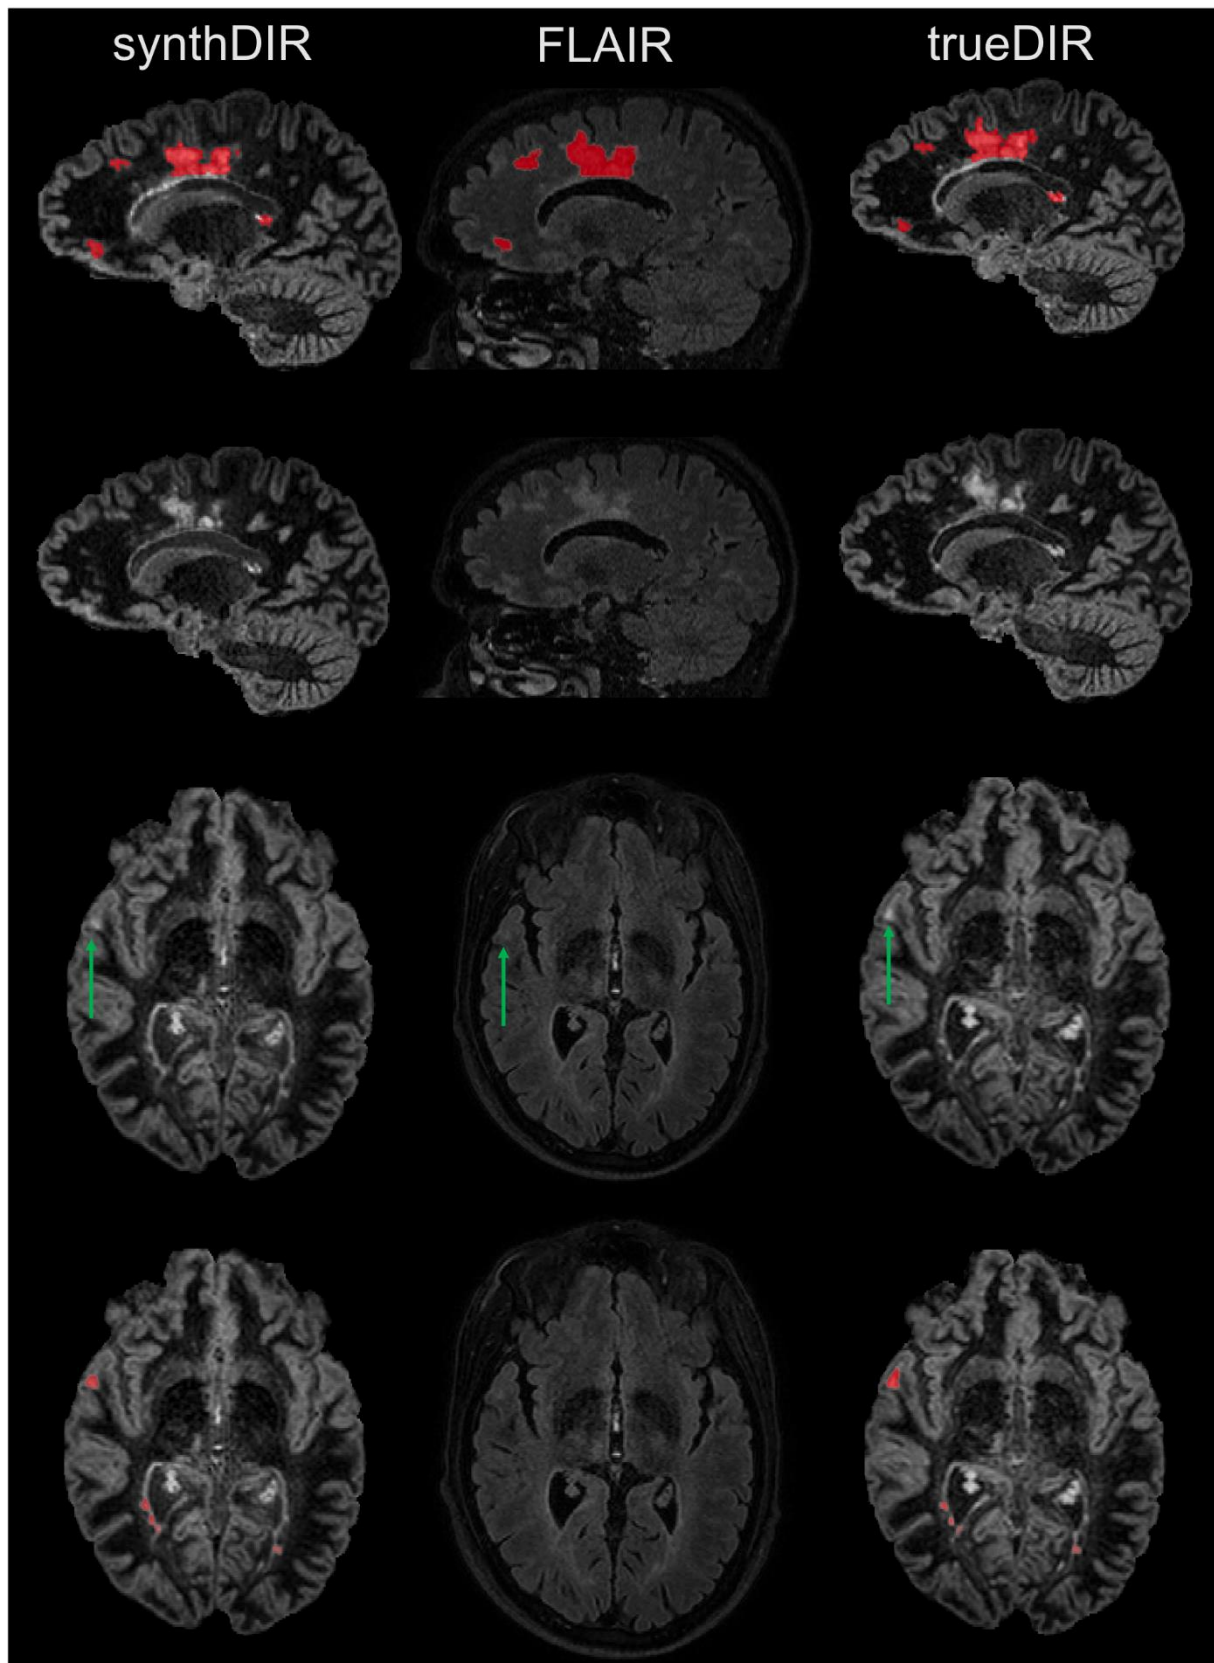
Exemplary images of FLAIR, synthDIR and trueDIR from the same patient. Given are sets of slices in the sagittal and axial plane with their respective lesion segmentations. Notable is the improved ability to detect juxtacortical lesions (green arrows) in synthDIR compared to (input) FLAIR.
